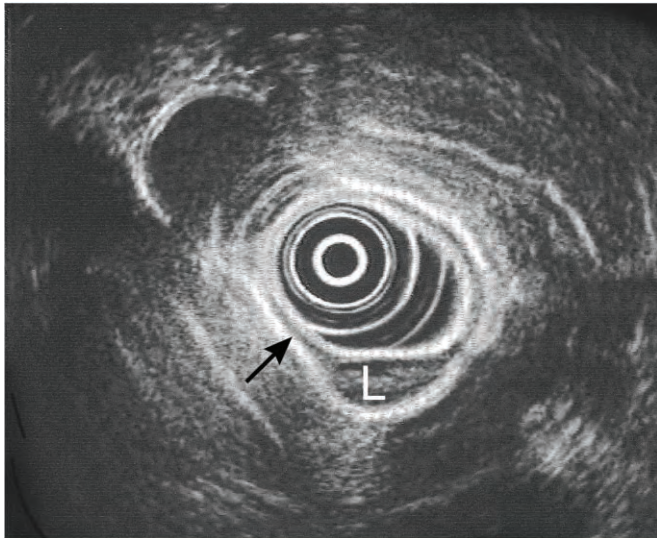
Esophageal leiomyoma. *Upper*, Endoscopic ultrasonography (EUS) of this most common benign tumor demonstrates a hypoechoic, homogeneous, well-demarcated tumor with no associated lymphadenopathy. EUS balloon overdilatation blends the first three ultrasound layers into one hyperechoic layer. The tumor arises from and is confined to the fourth ultrasound layer (*arrow*). *Lower*, A benign leiomyoma arises from and is confined to the muscularis propria.
